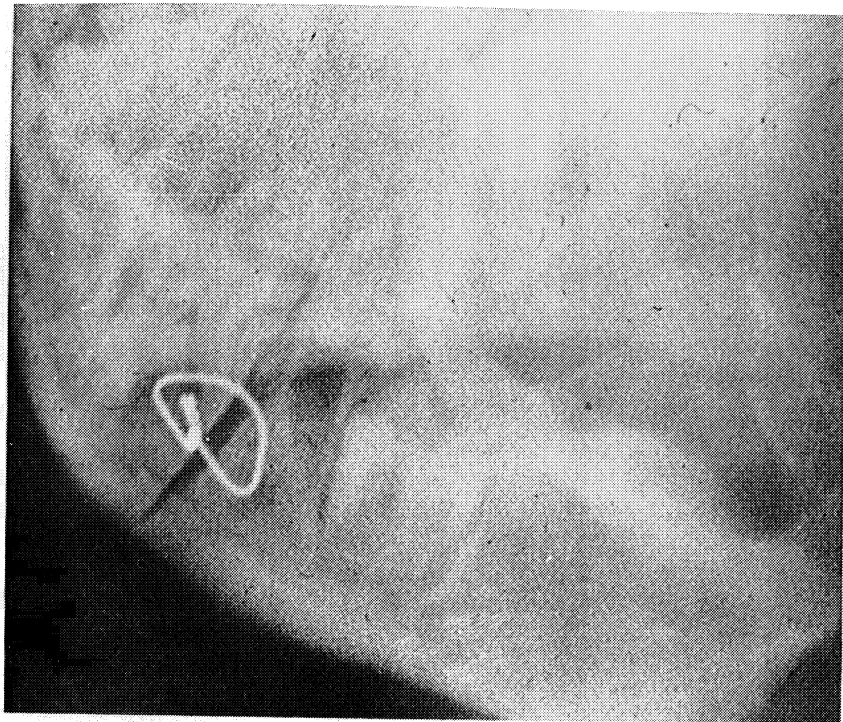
Horizontal radiograph of one millimeter tissue section from clinical nonunion. Observe the extreme buccal and lingual anchoring callus, the bony eburnation, and lack of bridging or uniting calcification.
